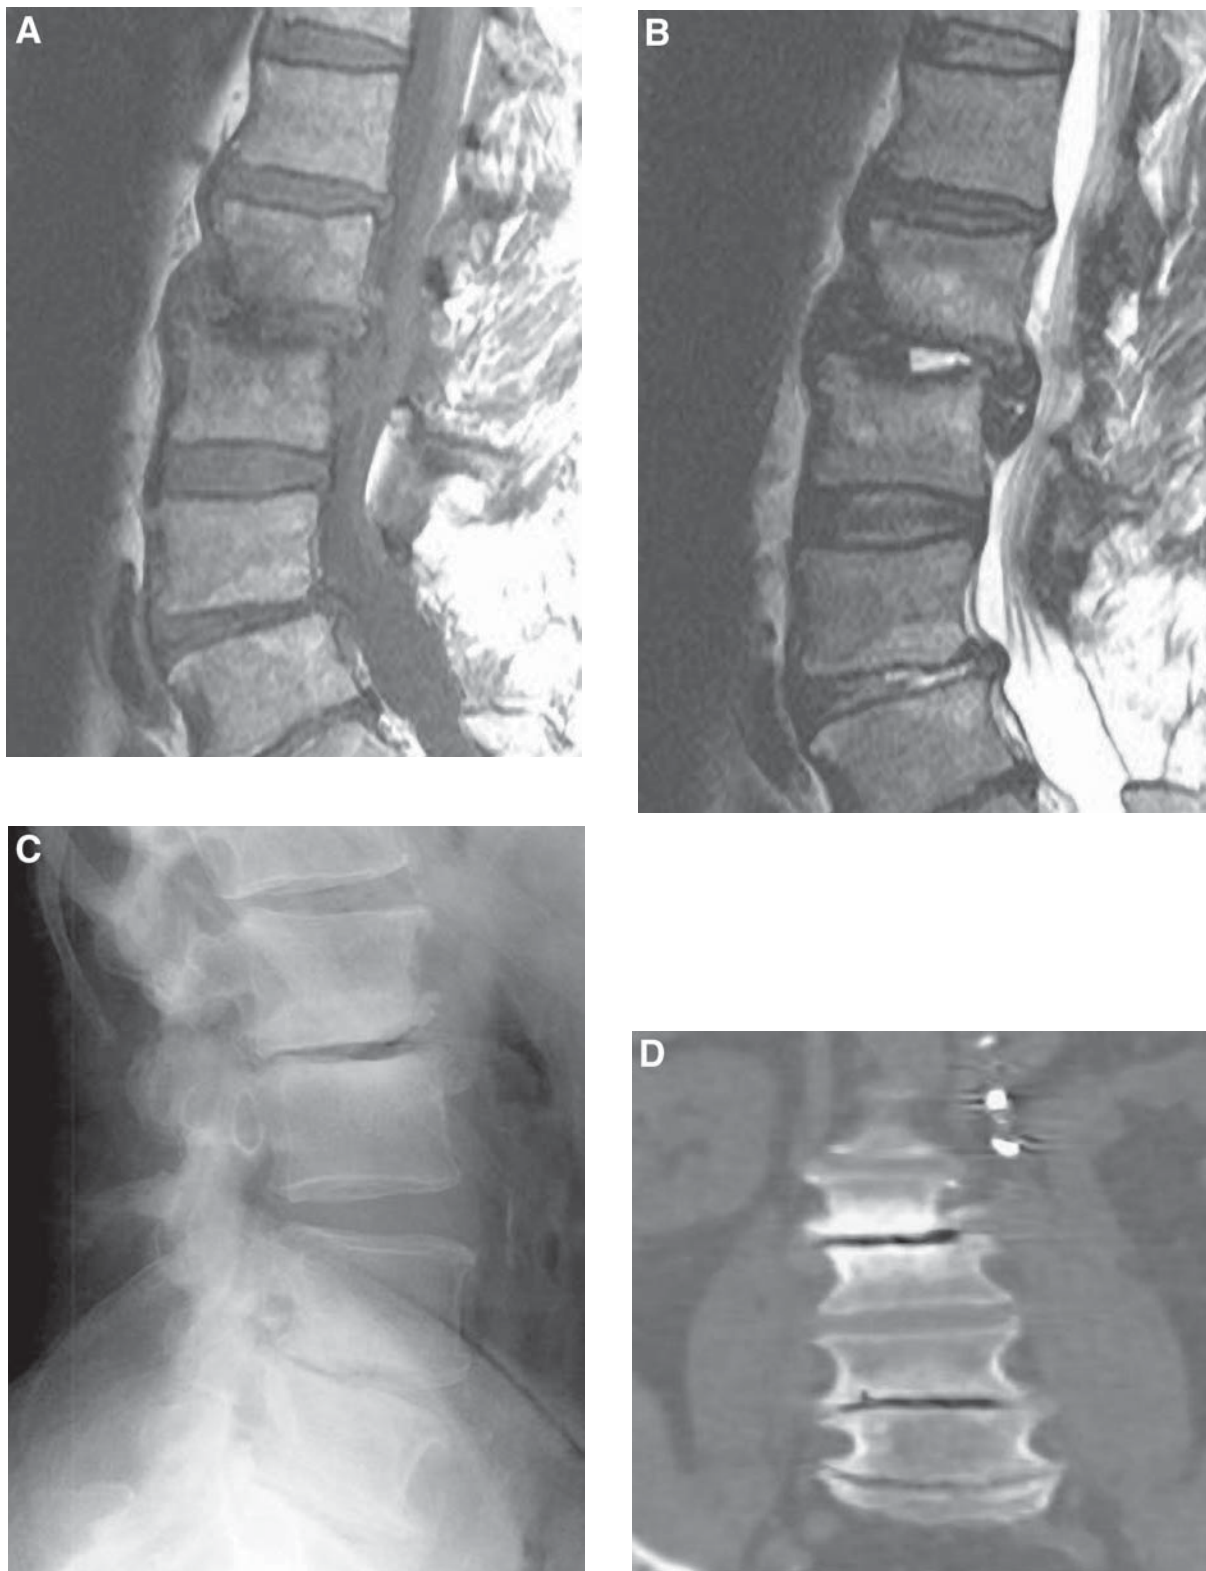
Sagittal T1- (A) and sagittal T2-weighted images (B) demonstrate endplate edema and fluid in the disc space at L2–3, findings usually associated with discitis. Note the relative preservation of the vertebral endplates and the similar changes at L4–5. A large disc extrusion is also present at L2–3. (C) Lateral radiograph reveals degenerative endplate sclerosis, osteophytes, and an intervertebral vacuum disc at L2–3, which virtually excludes the presence of discitis. (D) Coronal CT reformation is derived from a routine abdominal CT performed for an unrelated reason. It shows the remarkable resolution that is attainable with MPRs, even from a nondedicated exam. Also note the vacuum cleft at the L4–5 space.
